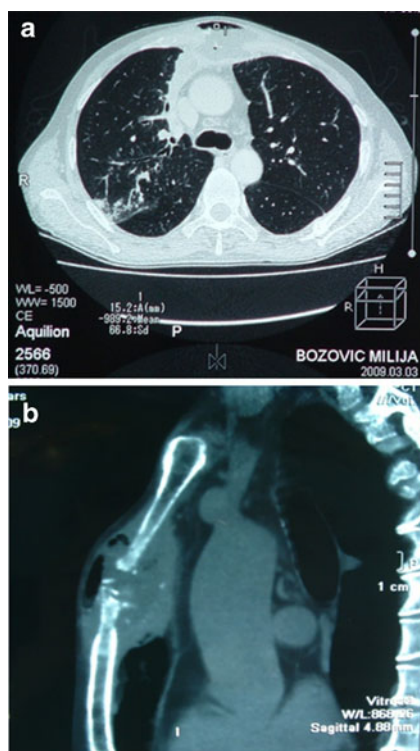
a and b Initial CT scans of the chest showing infiltration in sternal region (CT, computed tomography)
